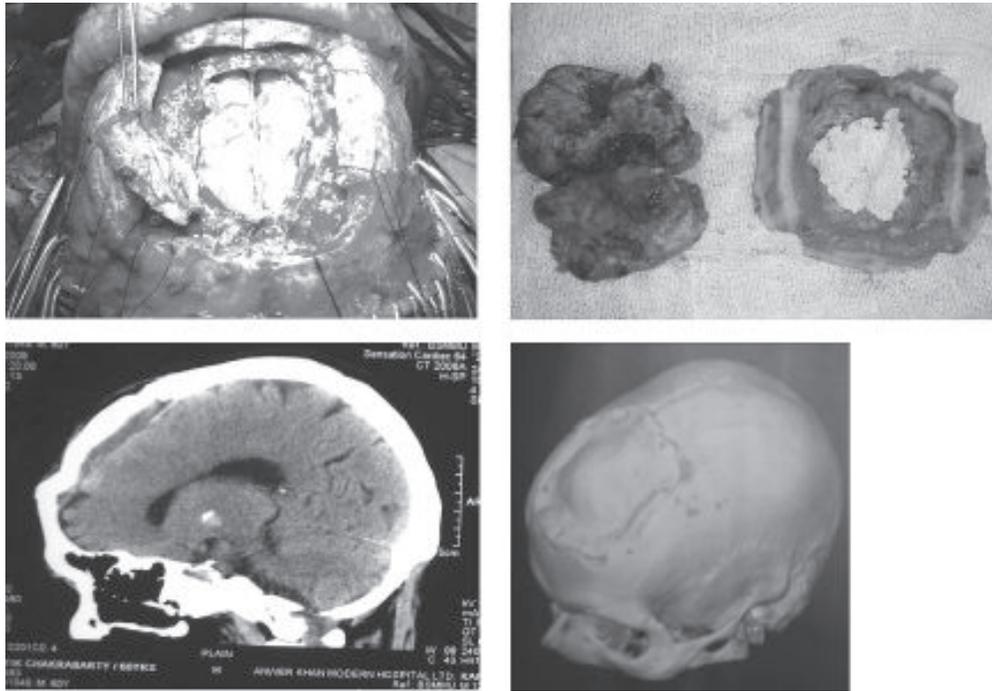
Per operative picture after removing the bone and involved portion of dura mater. Tumor and involved bone on the top right side. Bone shows osteolytic area. Post operative CT scan shows total removal of the tumor and 3D picture shows cranioplasty areas in the frontal region.
